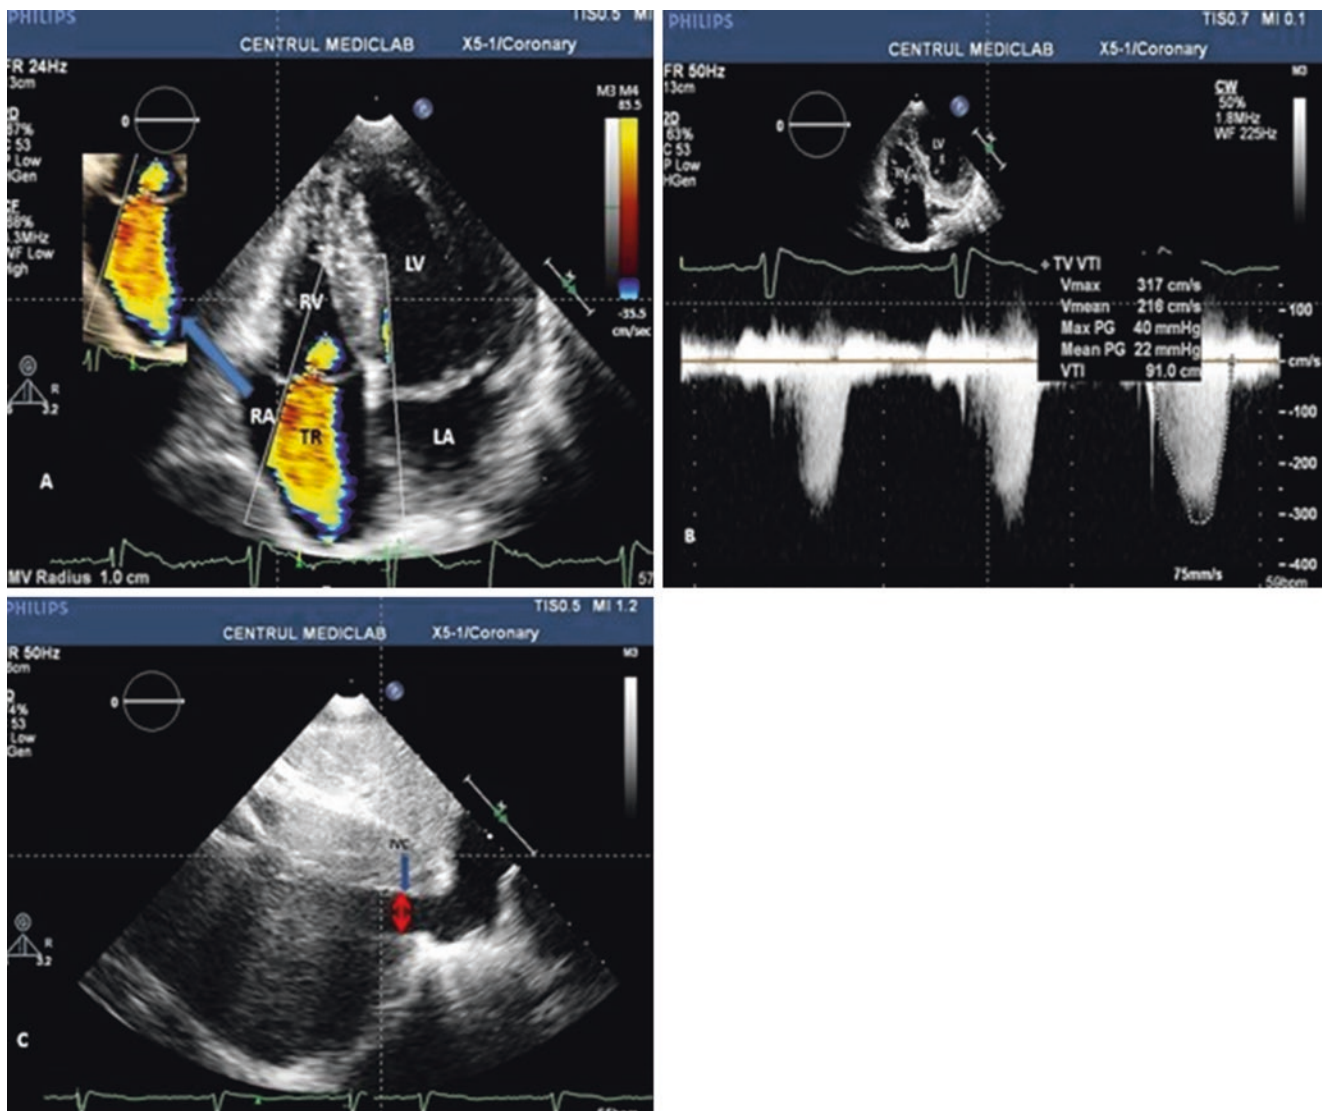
Transthoracic echocardiographic evaluation of the sPAP (a) color Doppler tricuspid flow interrogation. Severe TR, with PISA (medallion). (b) continuous Doppler tricuspid flow interrogation. Maximal velocity of TR flow is 317 cm/s; maximal RV-RA gradient is 40 mmHg, according to the Bernoulli equation. (c) IVC diameter (2D
